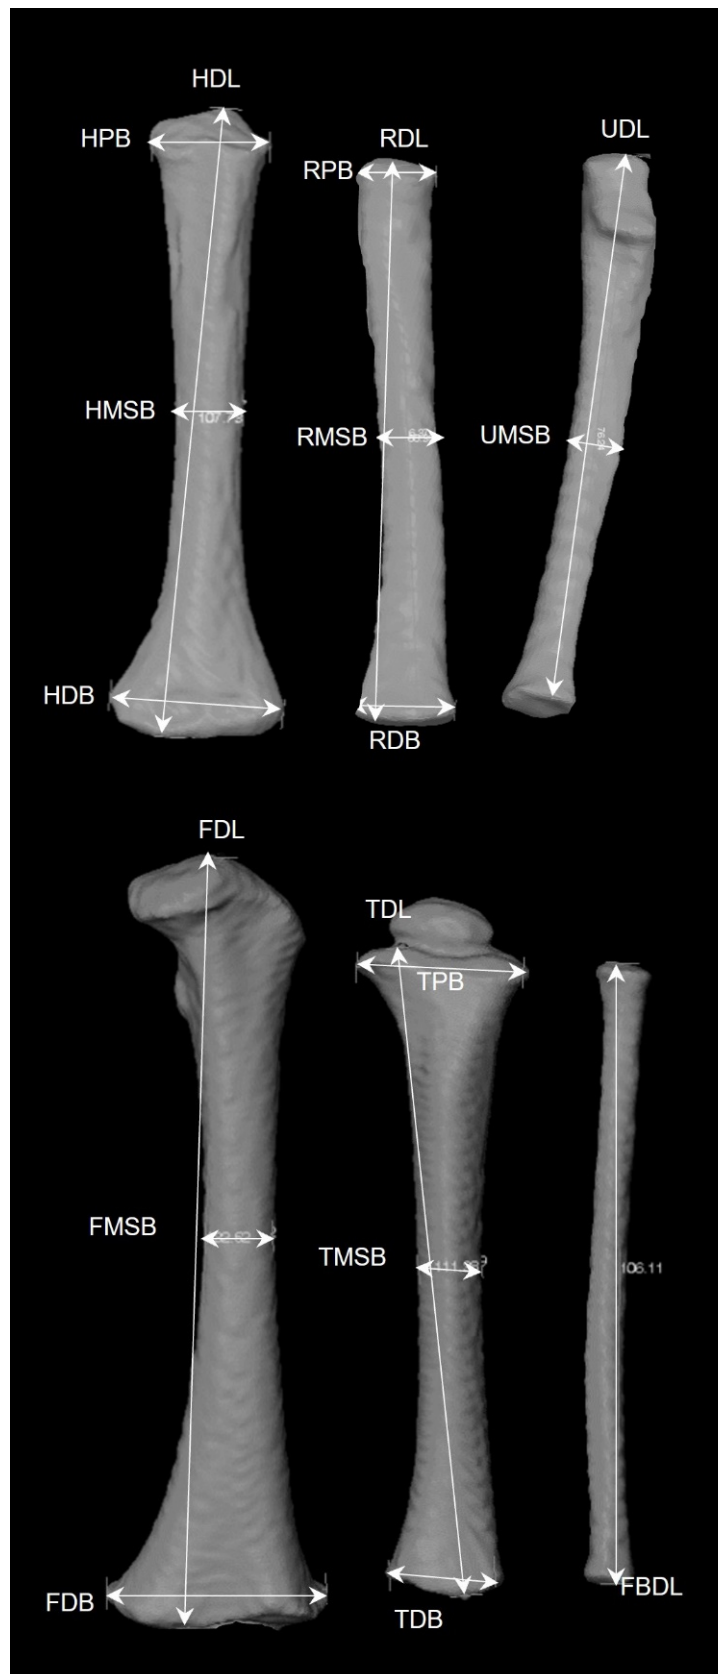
Long bone dimensions taken on virtual surfaces reconstructed from CT scans.
